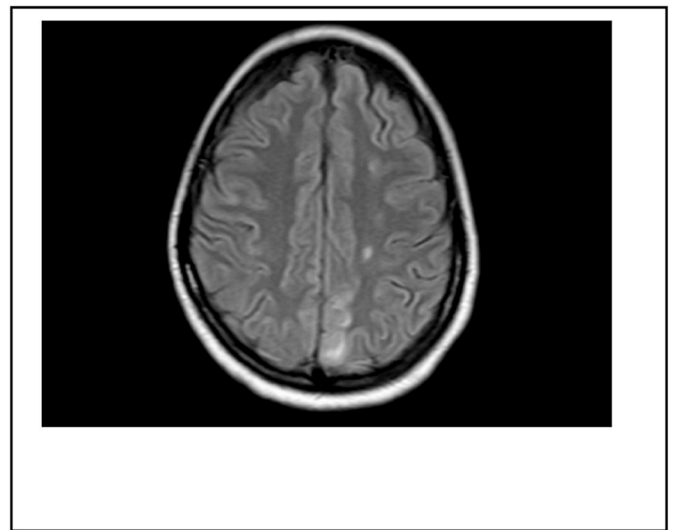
MRI examination-hyperintense lesions in the left posterior parietal region.
